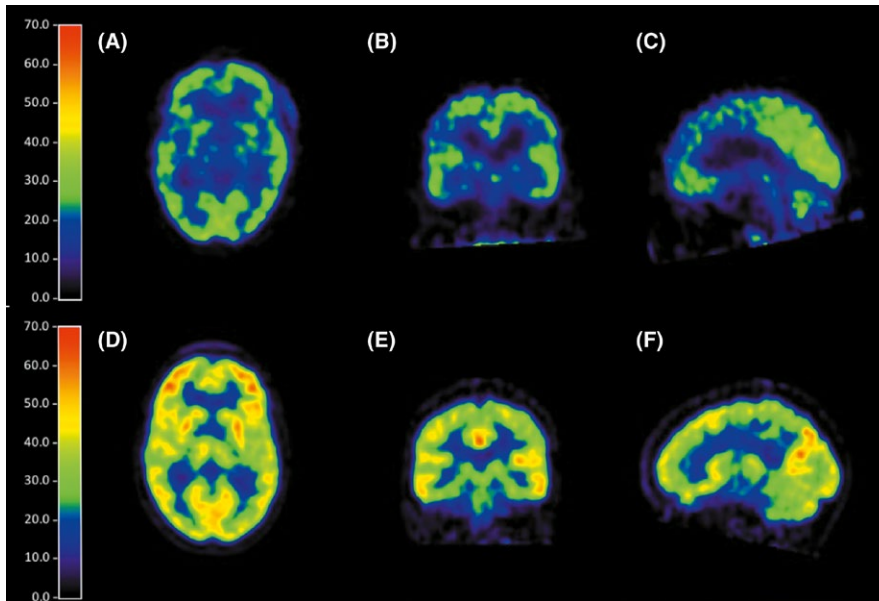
FDG-PET images of the most severely affected patient (Patient 5, A-C) compared with a healthy control (D-F). Axial (A, D), coronal (B, E), and sagittal (C, F) images showing decreased glucose metabolism in the patient
